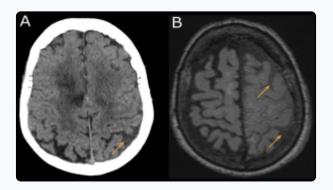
Comparison between CT and MRI. CT (A) showing (orange arrow) hyperdensity in the subarachnoid spaces of the parietal convexity. MRI (B) showing FLAIR hyperintensity (orange arrows) in the same area.
